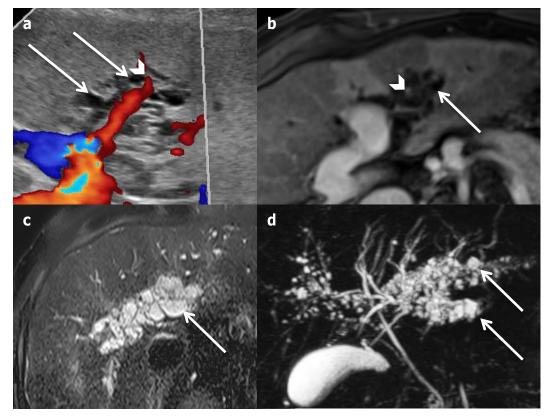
Peribiliary cyst in a 69-year-old cirrhotic male patient. (a) Ultrasonography shows multiple periportal (arrowhead) cysts (arrows). (b) The portal vessels are clearly visible (arrowhead) at axial portal-venous phase magnetic resonance imaging, assessing the periportal location of the cysts. (c and d) Axial T2-weighted magnetic resonance imaging and magnetic resonance cholangiopancreatography show multiples small cysts along thin, non-dilated bile ducts.
